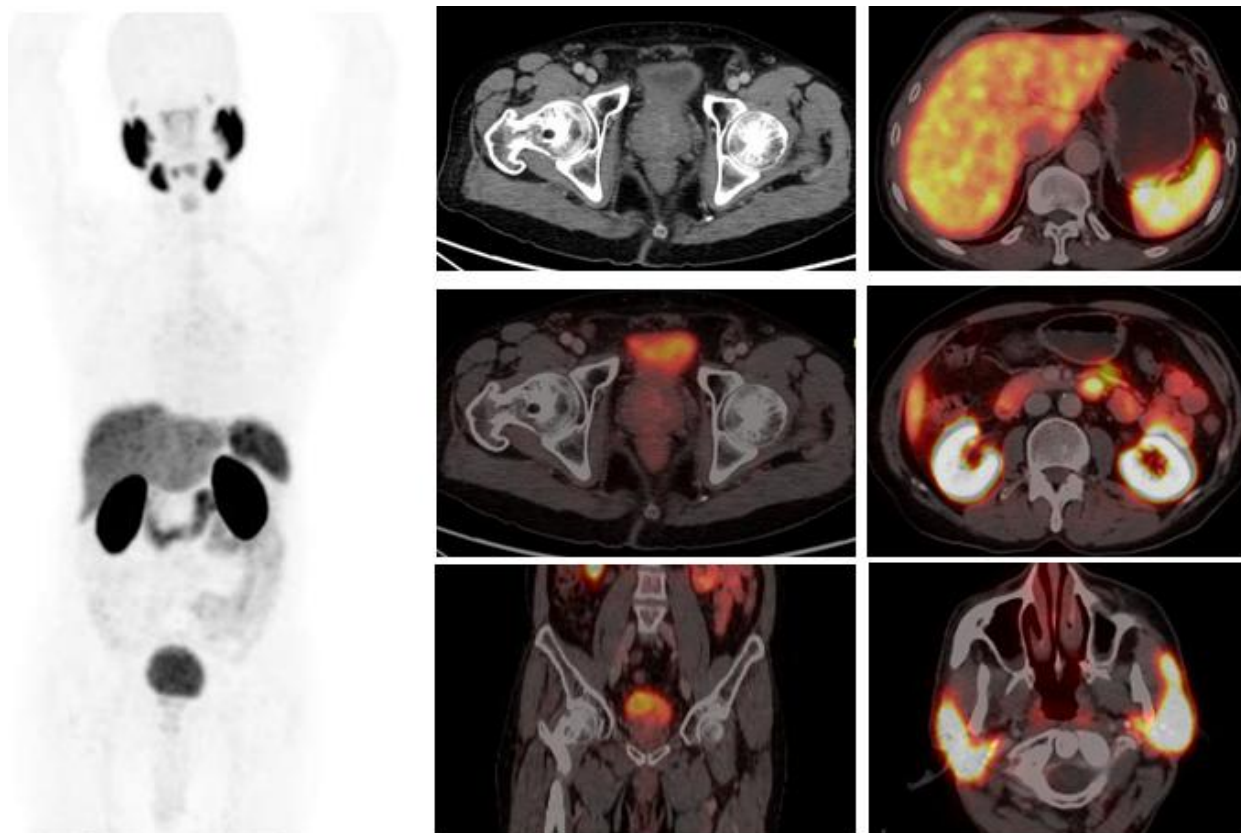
A 74-year-old male is a known case of prostate cancer with Gleason score 7 (4+3) treated with prostatectomy 2years back. Now complaining of back pain with slow rising PSA 0.24ng/ml. ^{68}Ga -PSMA-11 PET-CT performed after injection of 3.6 mCi ^{68}Ga -PSMA-11. a) Anterior MIP b) Coronal c) Transaxial fused PET-CT images show physiological activity within the lacrimal glands, the parotid and submandibular glands, the nasal region, the kidneys and the urinary bladder. A mild to moderate tracer localization is noted at the duodenum and the small bowel representing physiological uptake. No abnormal tracer localization seen. Findings are negative for any disease recurrence.
